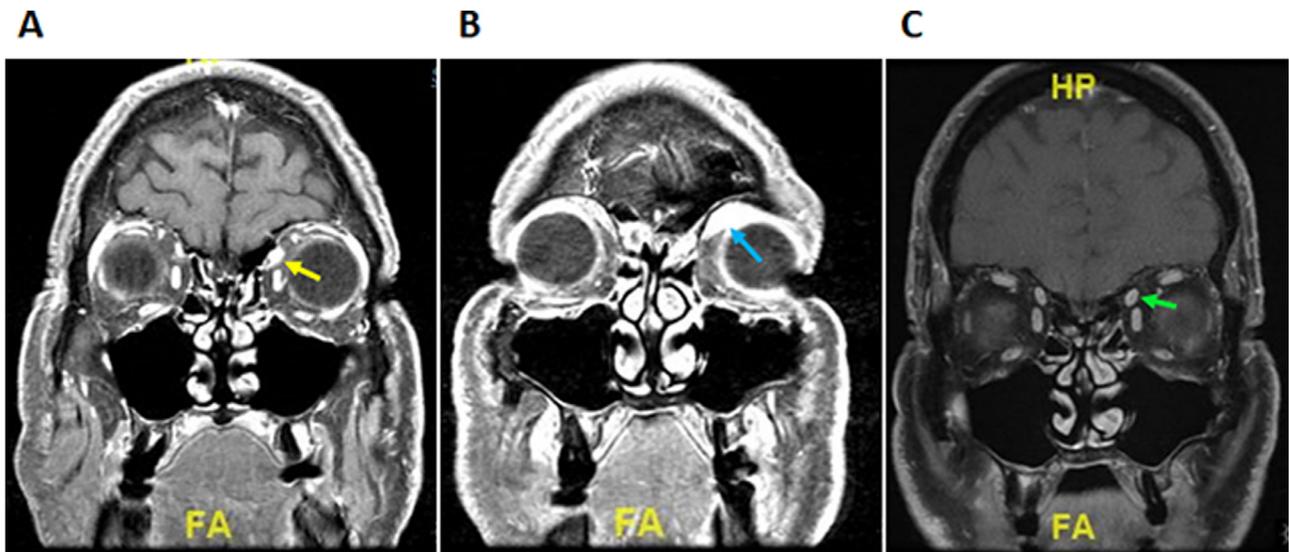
Gadolinium-enhanced T1-weighted fat-suppressed coronal MRI images demonstrating enhancement of the left superior oblique muscle (A, yellow arrow) and anterior left superior orbital soft tissue (B, blue arrow). Repeat imaging at a 2-month interval demonstrated resolution of the left superior oblique muscle enhancement (C, green arrow).
